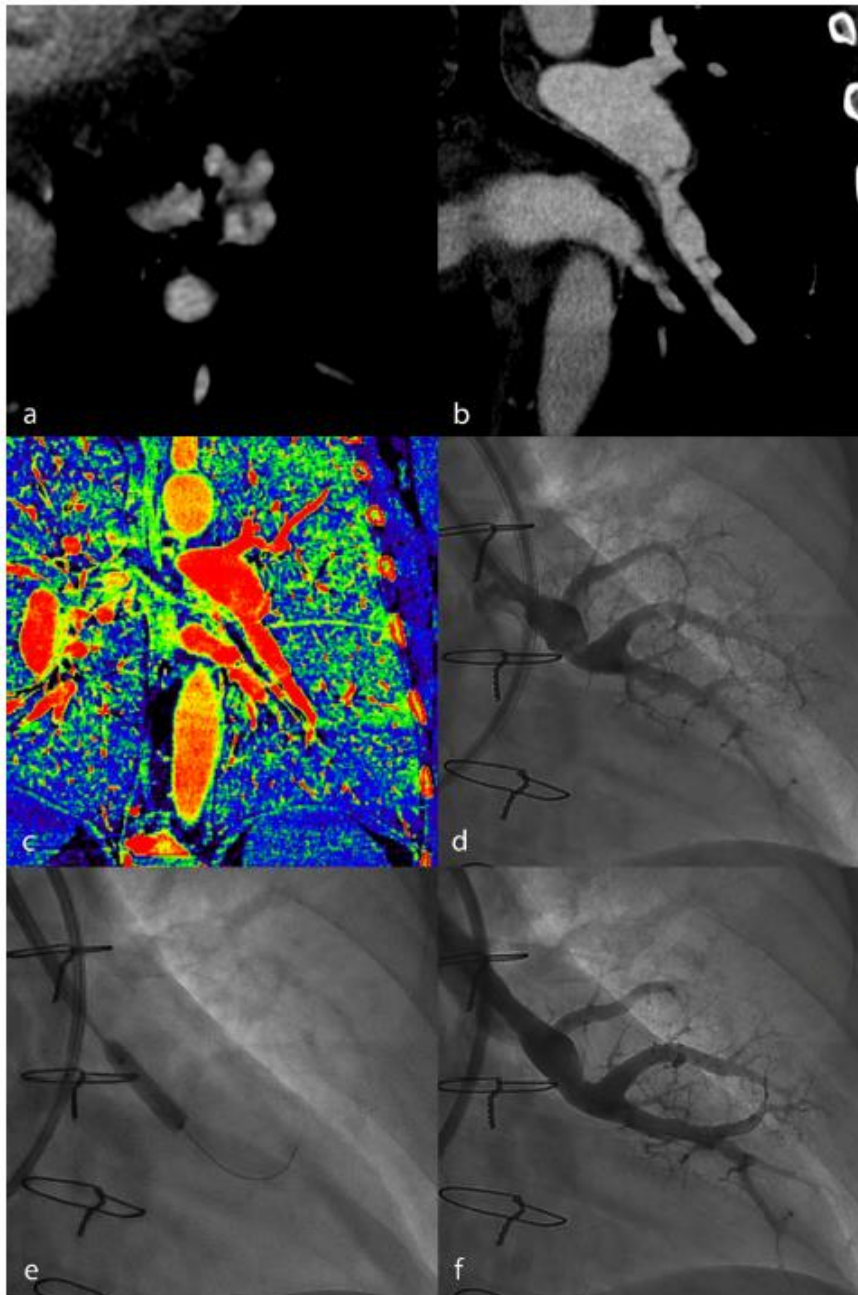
Dual-energy CT pulmonary angiography shows several webs in the left lower lobe's anterior and lateral segmental arteries on axial (a) and coronal reformatted (b) images. Coronal reformatted iodine density map reveals impaired perfusion in the left lower lobe (c). Selective transcatheter pulmonary angiography shows incomplete opacification of the anterior segmental artery due to webs (d). Following treatment with balloon pulmonary angioplasty (e), a final angiogram shows the absence of stenosis (f).
